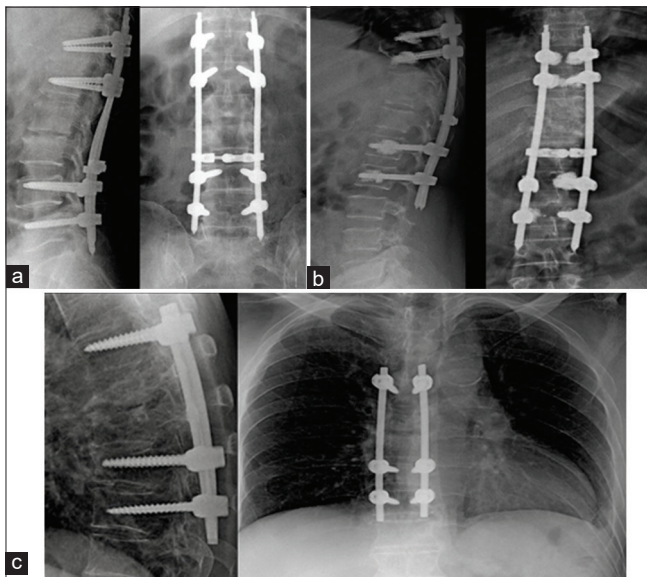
(a) post- opt X-ray Dorso-lateral spine- lateral and antero-posterior view- thoracolumbar minimal invasive pedicle screw with rods. The separate small midline incision at the level of involvement allowed us to perform laminectomy, decompression and horizontal connecting rod placement. (b) post- opt X- ray Dorso-lateral spine- lateral and antero-posterior view- thoracolumbar minimal invasive pedicle screw with bone cement augmentation for a patient with associated osteoporosis. (c) post –opt X – ray DL spine- lateral and antero-posterior view- open thoracolumbar fusion
